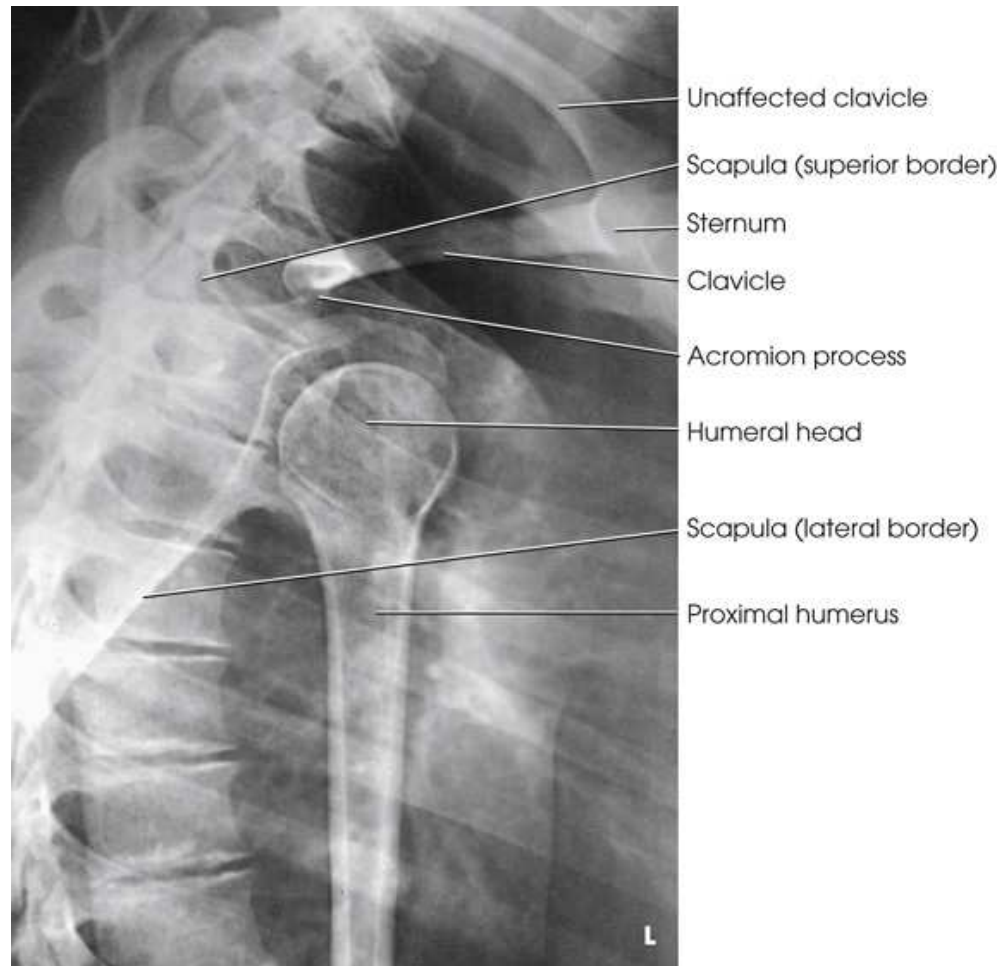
Transthoracic lateral shoulder: Lawrence method.
